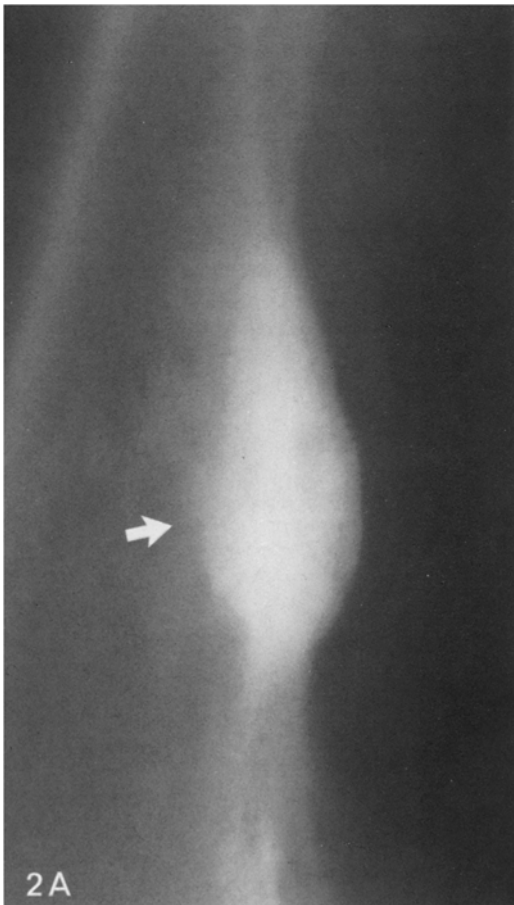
A, B. Parosteal osteosarcoma. A On lateral tomography of distal femur, dense tumor apparently extends into medullary cavity anteriorly (*arrow*). B On CT, tumor (*arrows*) cannot be distinguished from adjacent thickened bone cortex, but there is no medullary tumor extension. Note small lucencies within dense tumor
